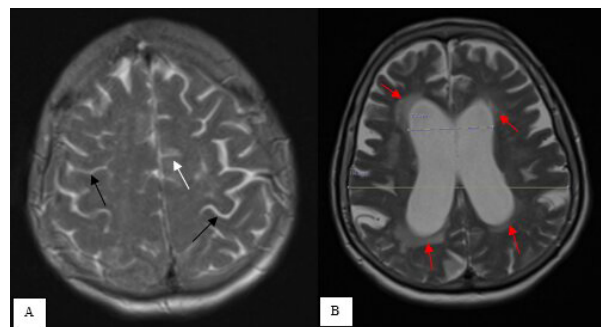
The brain axial T2w MRI showing disproportionate changes in the subarachnoid space. The relatively narrow convexity (A, black arrows) and parafalcine (A, white arrow) sulci in contrast to more prominent ventriculomegaly with Evan's index of 0,38 (50/130) and associated transependymal edema (B, red arrows)
